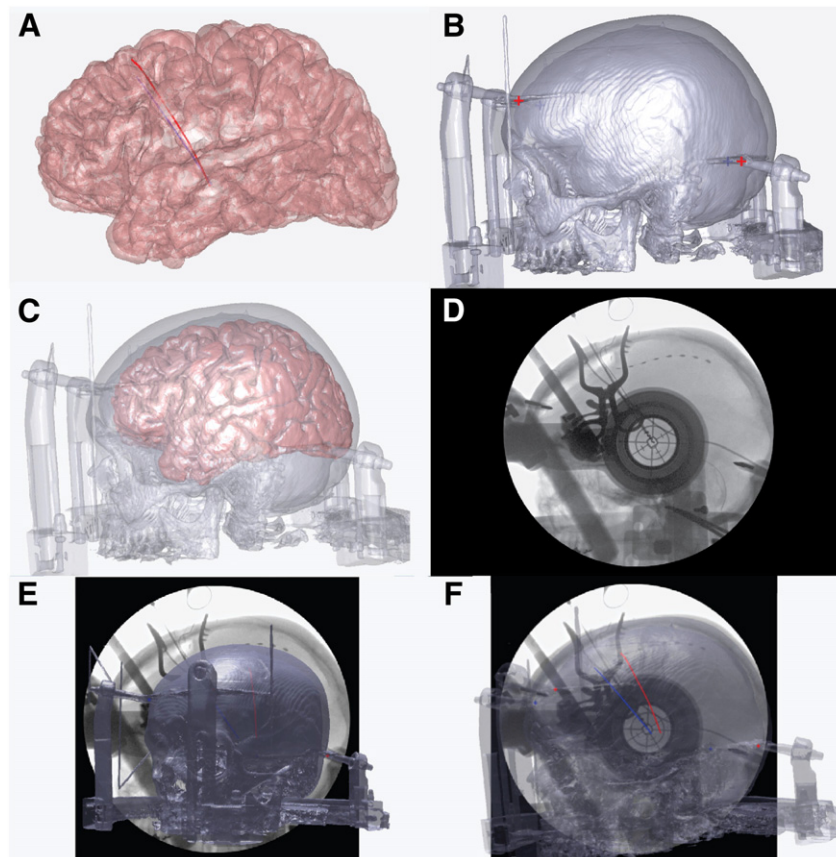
Fluoroscopic image registration. (A) Reconstructed 3-D cortical surface from the post-operative MRI with DBS electrode tracts are marked as red (left) and blue (right) paths. (B) Reconstructed 3-D skull surface with attached stereotactic frame calculated from a pre-operative CT. Stereotactic frame pin tips are labeled as red (left) and blue (right) crosses to assist with registration. (C) 3-D CT and MRI surfaces coregistered using normalized mutual information coregistration. (D) Clinical intraoperative fluoroscopic image with visible stereotactic frame pins, DBS electrode tracts, skull contour, and subdural ECoG electrodes. (E) Coregistered CT and MRI (not visible) surfaces overlaid in front of the fluoroscopic image in preparation for alignment. (F) CT and MRI (not visible) surfaces after being aligned laterally and scaled to match the general outline of fluoroscopic image.
